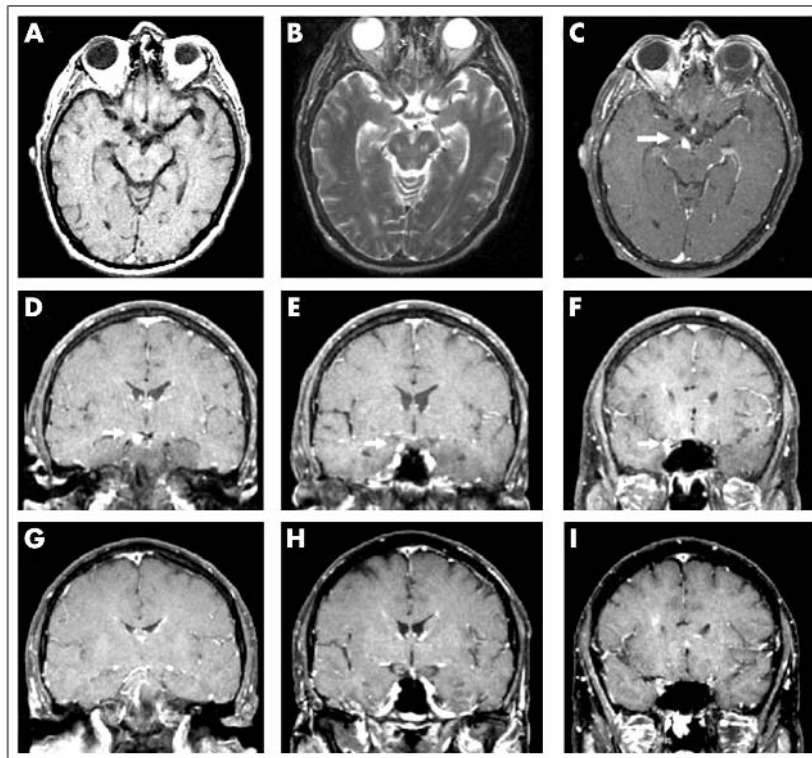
Head MRI showing the 8 mm (antero-posterior) × 6 mm (left to right) × 6 mm (rostral-caudal) tapering spheroid lesion at the base of the right midbrain, tracing the course of the oculomotor nerve forward into the cavernous sinus (panels A–F). The lesion is isointense to adjacent brain on T1 and T2 sequences (panels A and B) and enhances on a T1 sequence after gadolinium contrast (panel C). Pre-treatment (D–F) and post-treatment (G–I) coronal images demonstrate complete resolution at 7 months.
